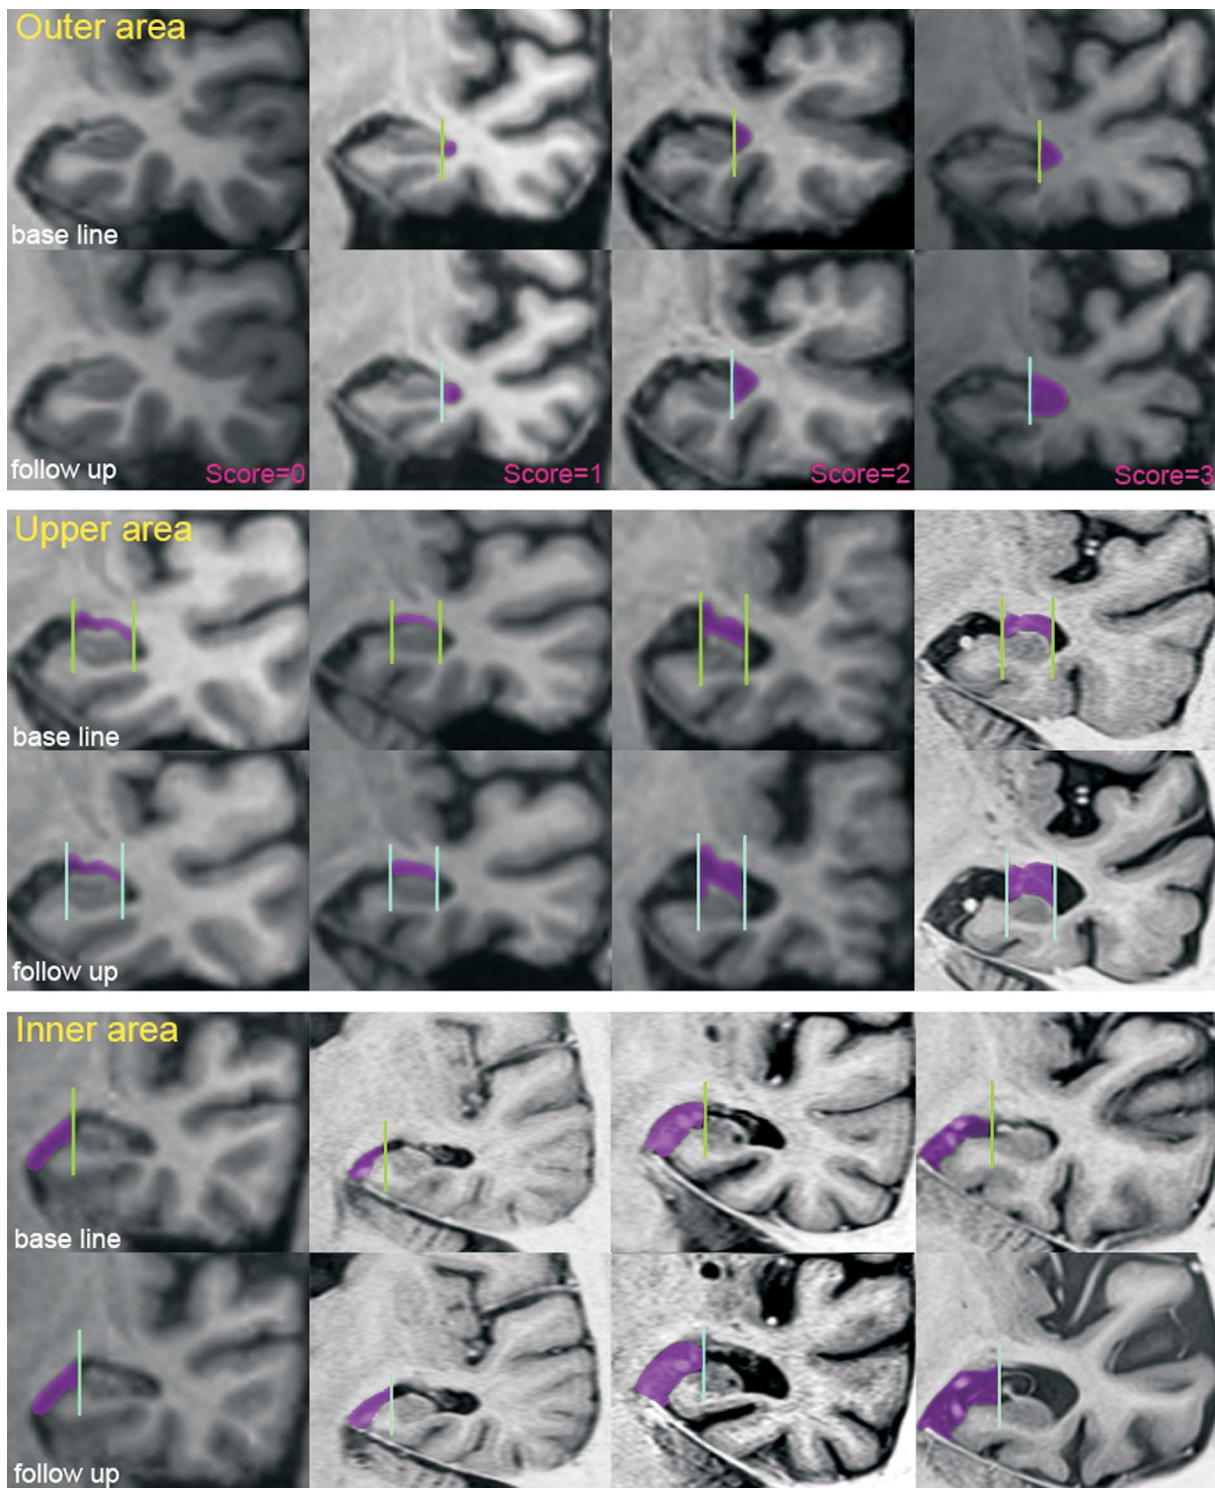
I-VRS at follow up MR imaging. This figure shows a representative image of those used to evaluate longitudinal VRS (I-VRS). The CSF space around the hippocampus was divided into three parts, in the same way as Figure 1A. The outer, upper, and inner areas are arranged from top to bottom. Each row has the upper base line image and the follow up image below, and four sets of the images arranged from left to right in accordance with the values of the VRS. Each area for evaluation is painted in pink. The extent of the CSF widening between the baseline and follow-up image was ranked as follows: score = 0: no difference; score = 1: slight widening; score = 2: remarkable enlargement; score = 3: severe enlargement from baseline to follow-up.
